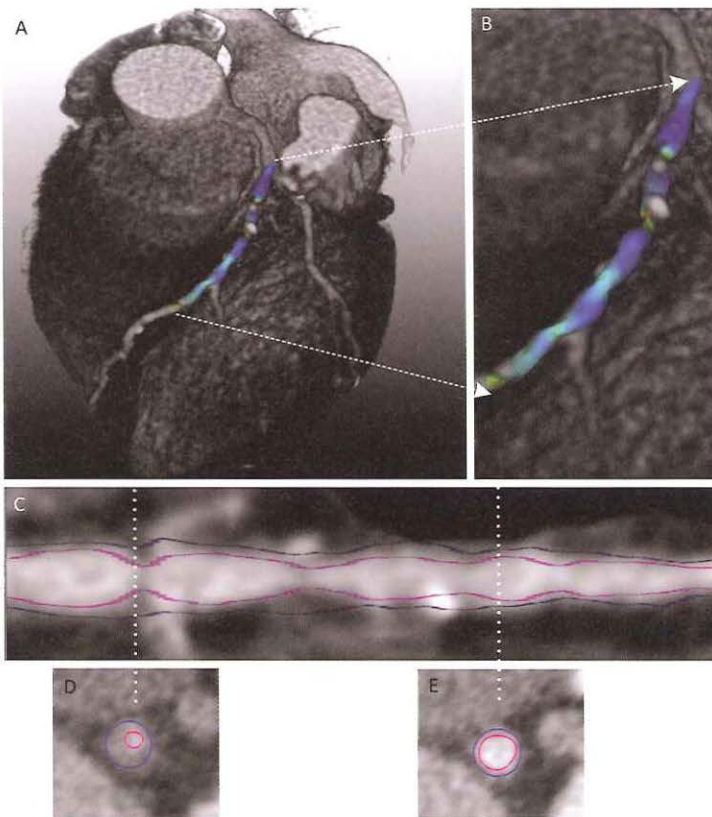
A: 3D CT dataset of the heart fused with the IVUS derived geometry of the lumen on which the calculated WSS values are depicted. B: Magnification of panel A. C: CT curved multi-planar reformatted image along the centreline of the diseased artery with the fused lumen (pink) and wall (blue) IVUS contours. D and E: Cross-sectional CT images at the indicated locations with the fused lumen (pink) and wall (blue) IVUS contours.
